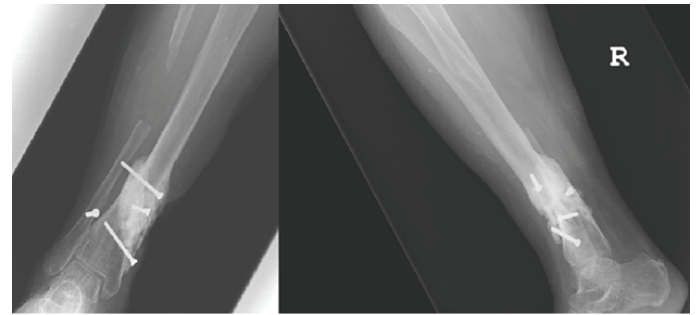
Post-reconstruction radiographs (anteroposterior and lateral) showing fixation and progressive consolidation after fibular strut grafting.
